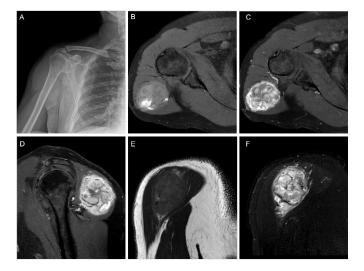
a. Direct radiography of the lesion, MRI with intravenous contrast, images of the lesion, b. axial T1, c. T2 axial with contrast, d. T2 coronal with contrast, e. T1 sagittal view, f. T2 sagittal view with contrast
